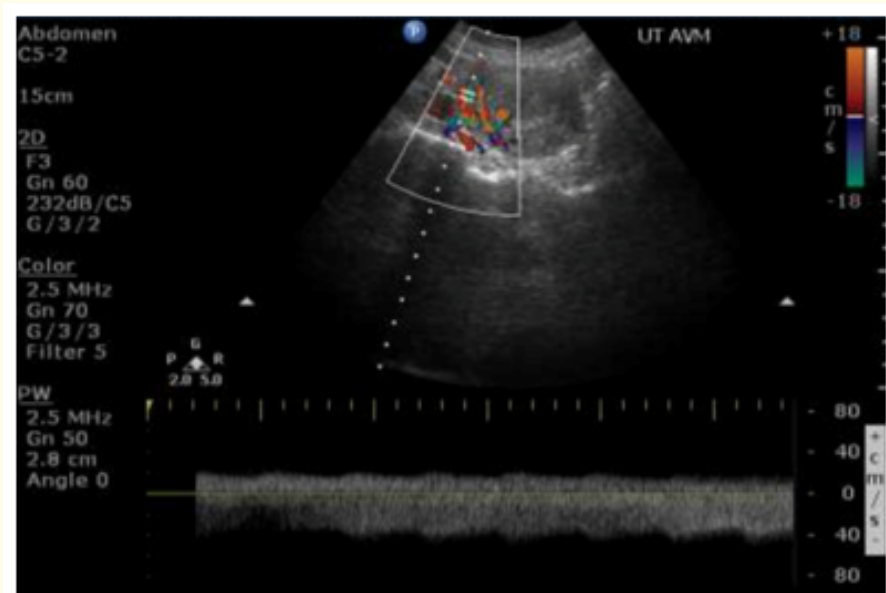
Spectral doppler study showing both arterial and venous wave pattern.
